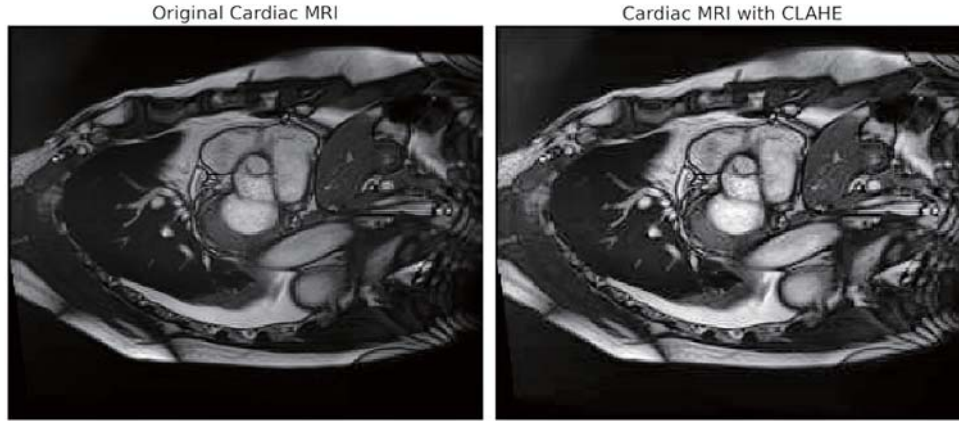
Cardiac MRI before (left) and after (right) CLAHE enhancement showing improved contrast and detail
